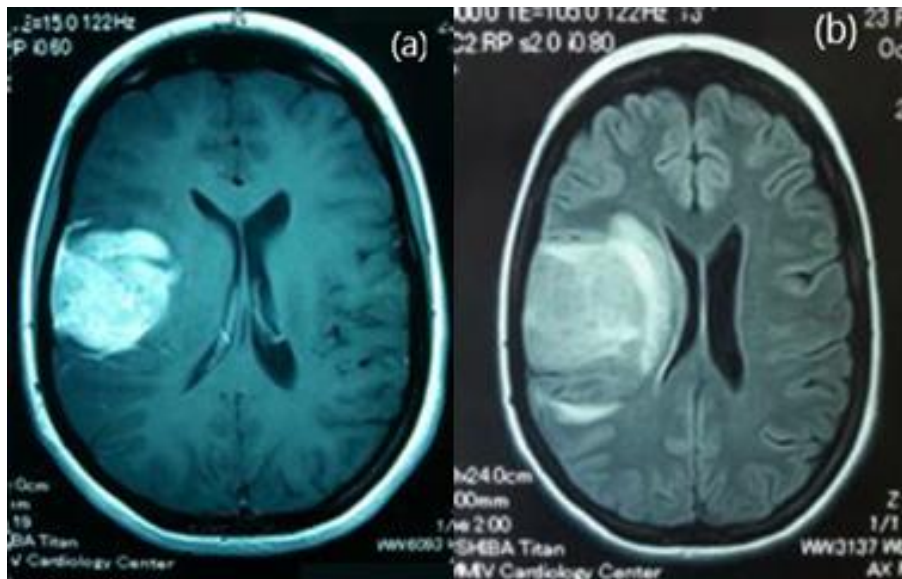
Axial T1-weighted contrast-enhanced MRI (a) and Flair MRI (b) showing a heterogeneously enhancing mass in the right temporoparietal region
